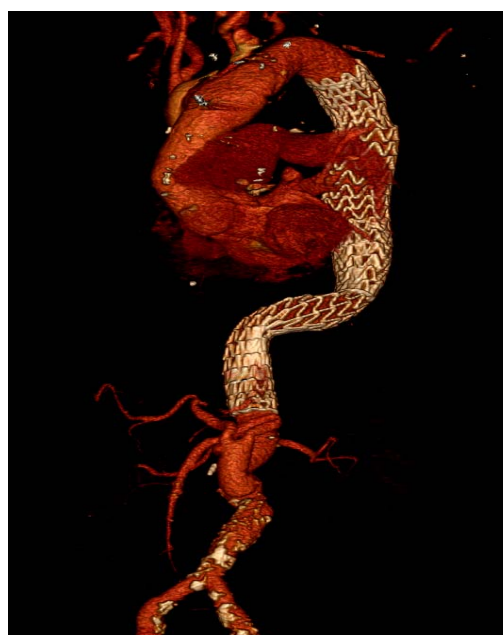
Control computed tomography scan 6 months after the endovascular repair.
